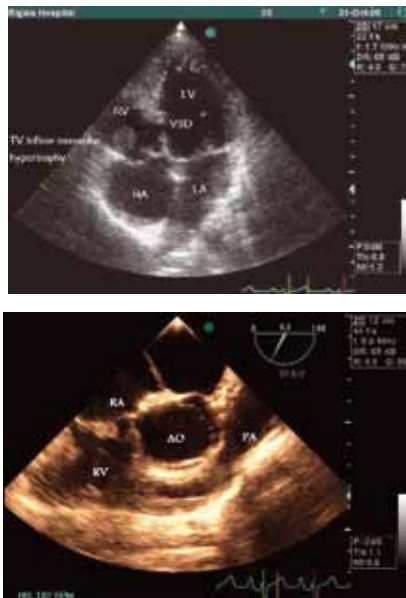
Echocardiographic images. (1a). TTE in four-chamber view showing hypoplastic RV with hypertrophied RV inflow associated with ASD and mid-muscular VSD. (1b) : TEE in RV inflow, outflow view showing hypoplastic infundibulum and main pulmonary artery.
